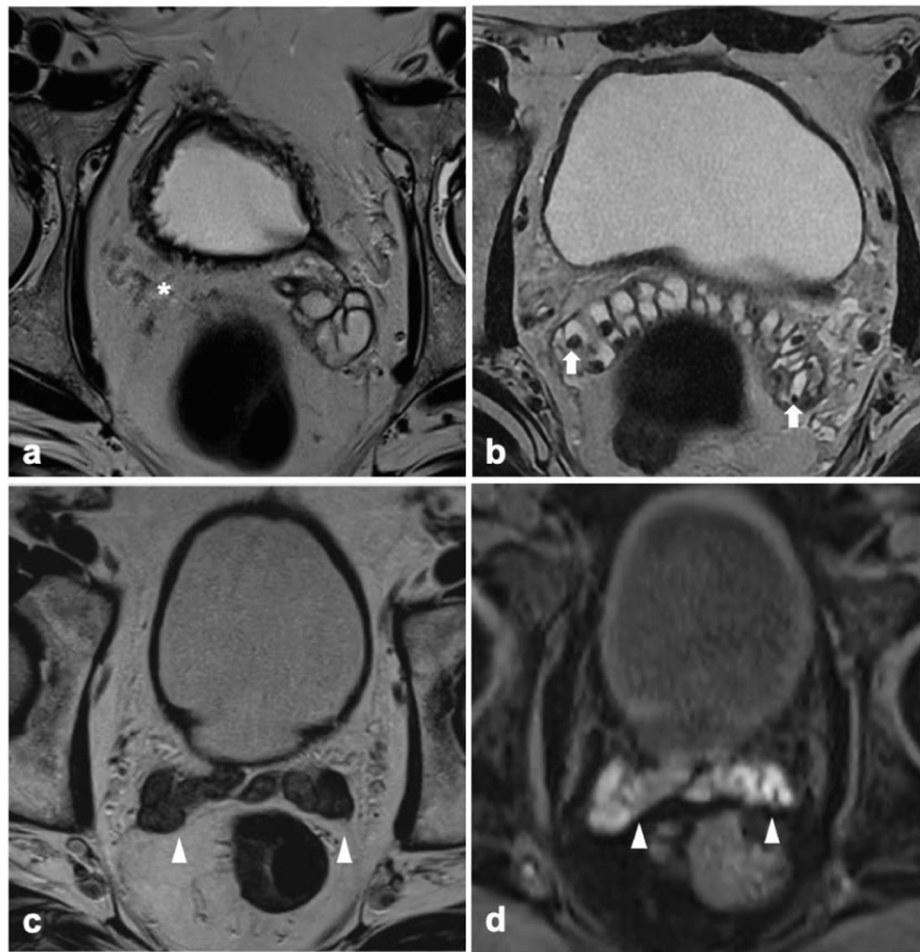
Axial T2w image (a) documents agenesis of the right seminal vesicle (asterisk). Axial T2w image (b) shows multiple rounded hypointense structures in both the seminal vesicles (arrows), in keeping with calculi. Axial T2w (c) and pre-contrast fat-sat T1w (d) images show respectively hypointense and hyperintense signal within both the seminal vesicle (arrowheads), findings suggestive of blood content. T2w T2-weighted, T1w T1-weighted.
